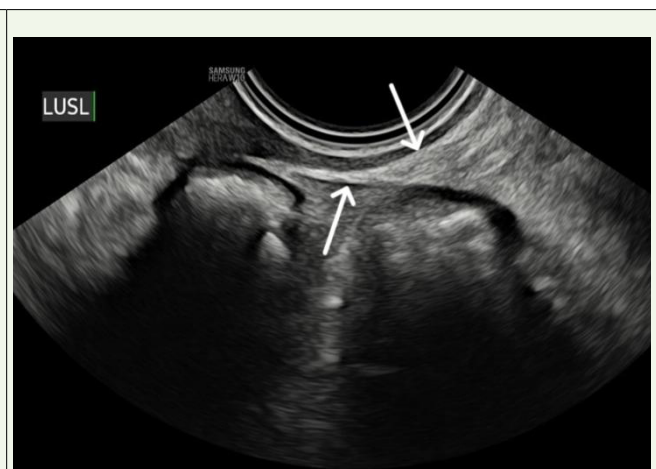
Normal sonographic appearance of the left USL.
